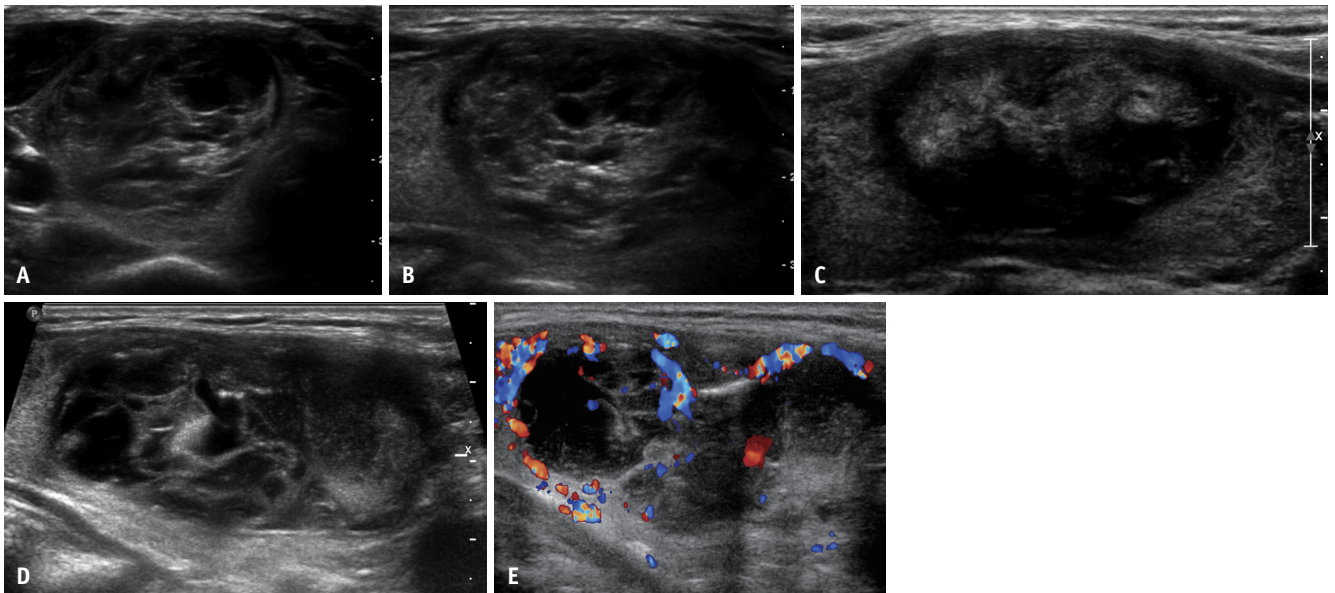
A 47-year-old female patient with encapsulated angioinvasive follicular thyroid carcinoma (FTC) in surgery after radiofrequency ablation (RFA). Ultrasonography shows a 3.7-cm-sized predominantly solid isoechoic nodule with an initial volume of 12.8 mL (A: transverse, B: longitudinal ultrasound [US] images). This nodule was classified as low suspicion at US and confirmed as benign by two fine-needle aspirations. Six months after RFA, the mass reduced to 3.2 cm. C: Eight years after RFA, the nodule increased to a 4.9-cm predominantly solid hypervascular nodule (D, E: Doppler US image) with a volume of 26.5 mL. The core-needle biopsy results suggested follicular neoplasm, and a final pathology report after right lobectomy confirmed encapsulated angioinvasive FTC.
